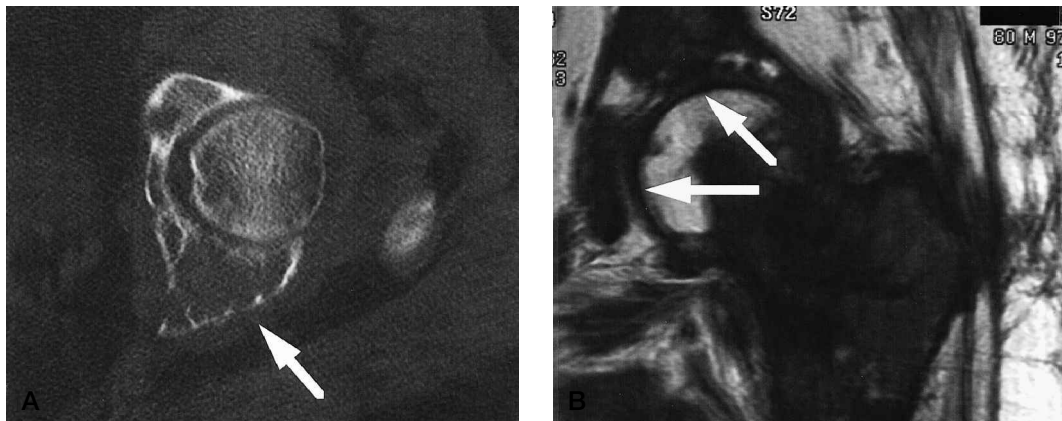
Preoperative assessment of the extent of metastatic tumor with (A) CT and (B) MRI.
